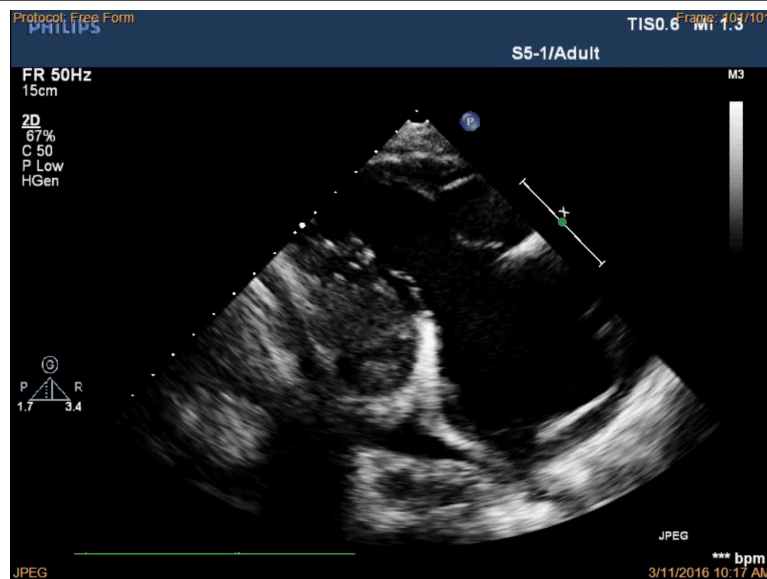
Transthoracic echocardiography from the parasternal view by tilting transducer inferomedially exploring the right atrium (RA) and right ventricle (RV) inflow tract; immobile leaflets of the tricuspid valve (TV) leading to severe insufficiency.
